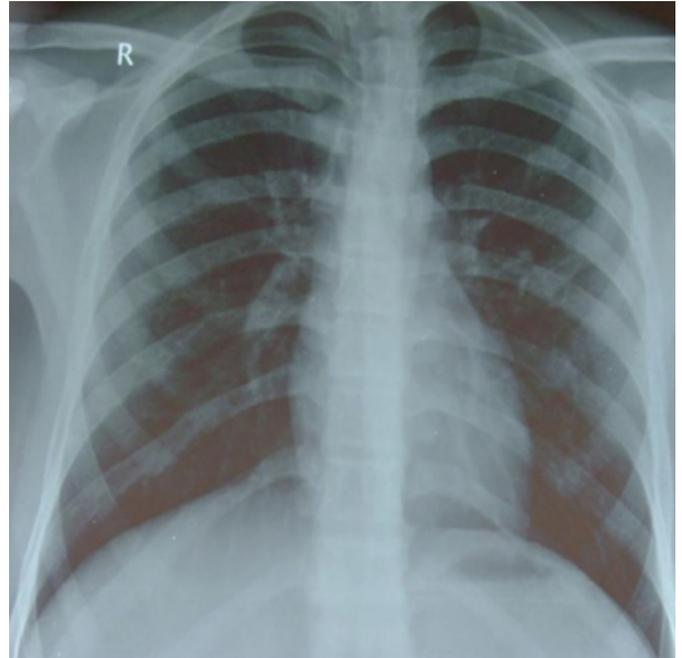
Chest radiograph showing bilateral diffuse pulmonary infiltrates consistent with pulmonary oedema.
